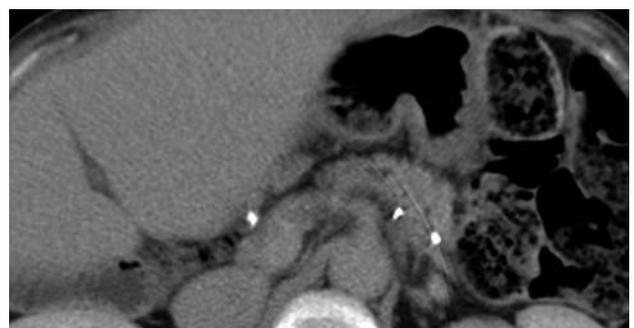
A radiograph showing postprocedure endoscopic naso-pancreatic drainage in case 1. Excellent drainage of the pancreatic duct is noted. ENPD: Endoscopic naso-pancreatic drainage.
